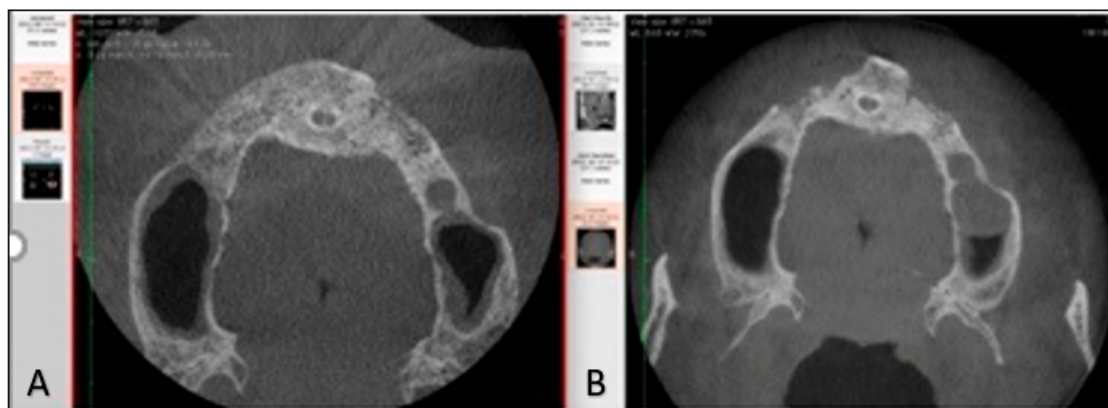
Axial view of the CBCT slide after 8 months following surgery. It shows good osteointegration at the bone material into the recipient site. Good bone density is shown as well. (A) Axial view after 8 months of the surgical operation. (B) Axial view before the surgical operation.
